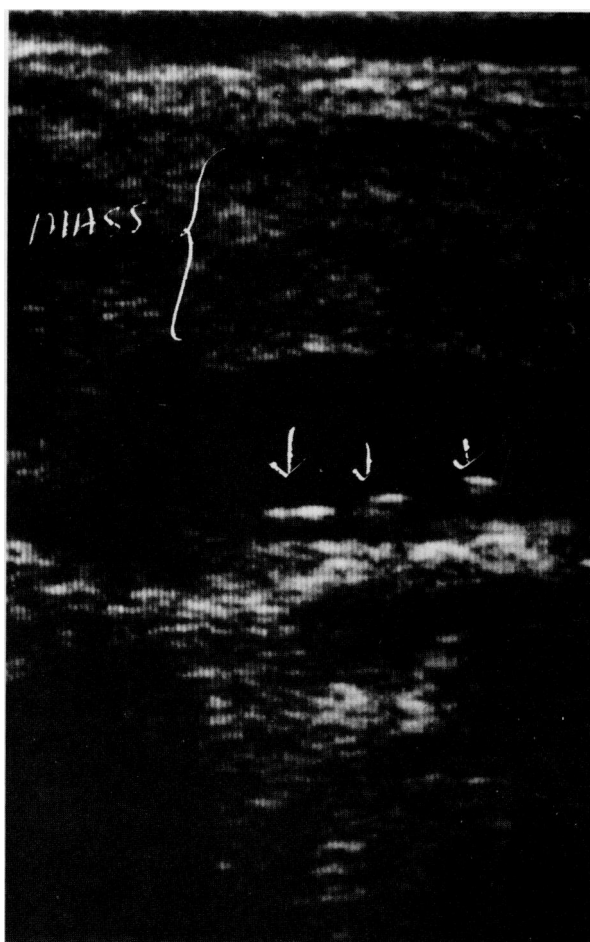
Sonogram of a type 2 perforation demonstrating a gallbladder, stones, pericholecystic hypoechoic areas, and inflammatory mass
